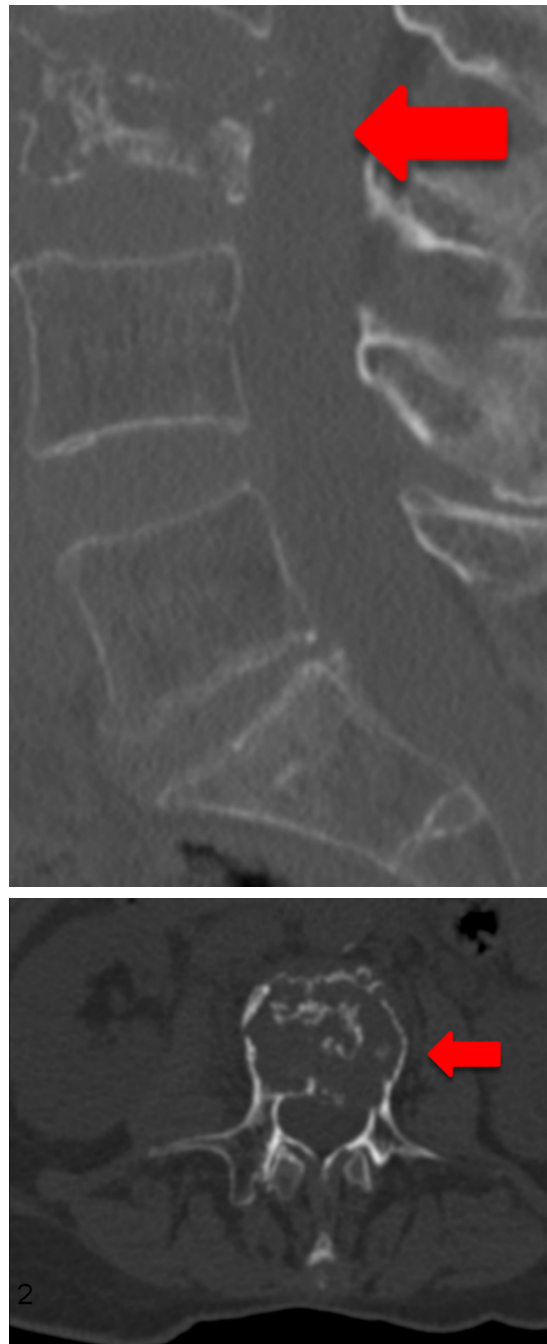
73-year-old female patient with multiple metastatic breast cancer ER: 95%; PgR: 0%; HER2-Score 1+; Ki-67: 20%. Sagittal and axial section of a total spine CT scan: unstable metastatic destruction of L3
